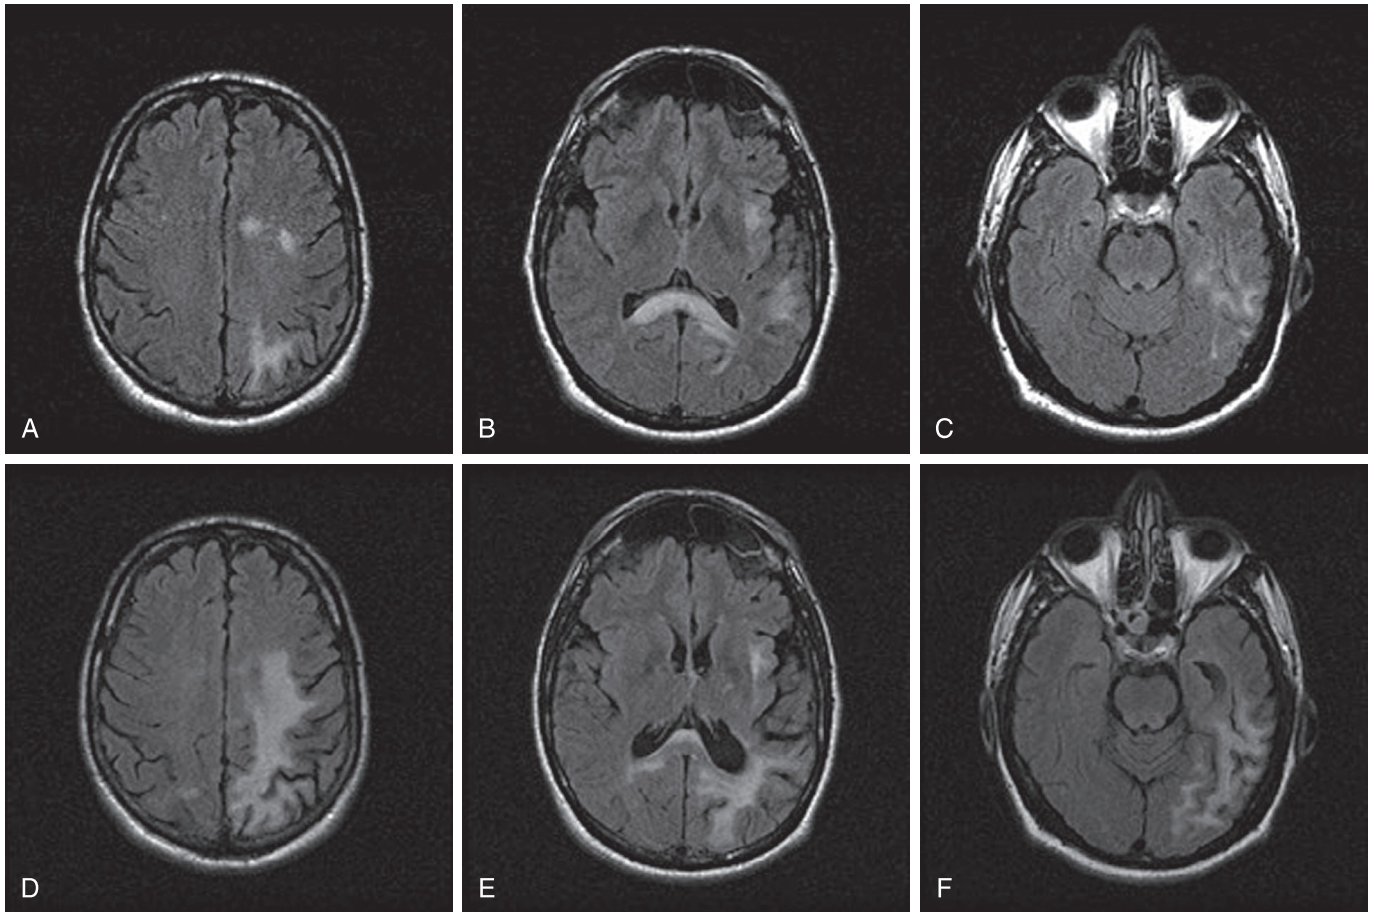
Progressive multifocal leukoencephalopathy (PML) case example. A 44-year-old male, HIV positive, presenting with 1 month of progressive neurologic changes. CD4: 148; cerebral spinal fluid: JC virus DNA positive. Axial FLAIR images (A–F). In early PML (A–C), the white matter lesions are multifocal and asymmetric, form a sharp border with the cortex, and have no significant local mass effect. In late PML (D–F), the lesions become larger and more confluent and there is associated atrophy.
